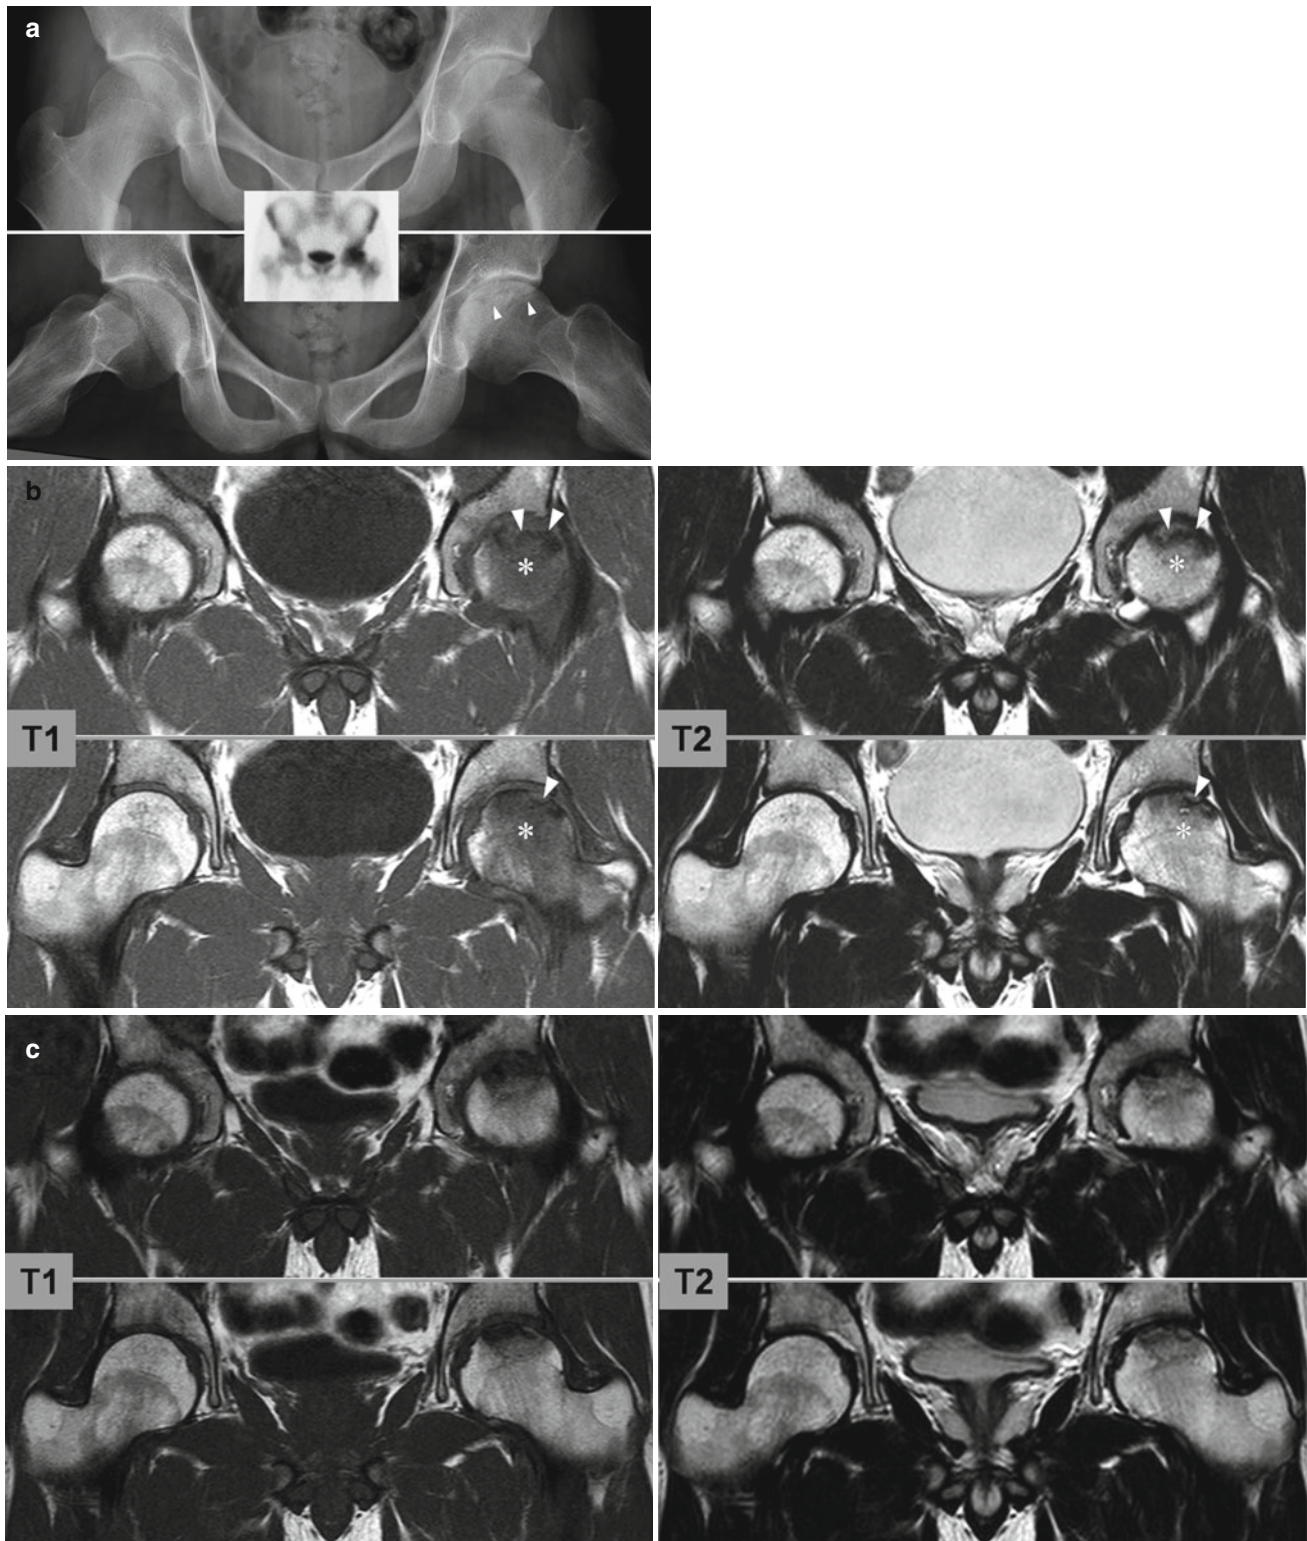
A 20-year-old man with fatigue-type subchondral stress fracture of the femoral head. (a) Plain radiographs taken 1 month after the onset of the left hip pain show mild flattening of the left femoral head and a subchondral fracture line (*arrow heads*). Bone scintigraphy shows increased uptake in the left femoral head (*inset*). (b) MR images taken 1 month after the onset of the left hip show a subchondral fracture
